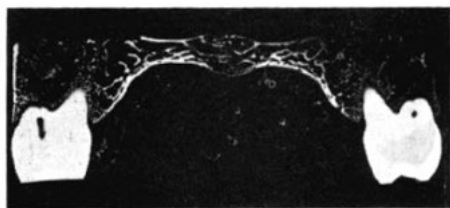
Soft x-ray radiograph demonstrating improved mineralization in sutural region after retention.
